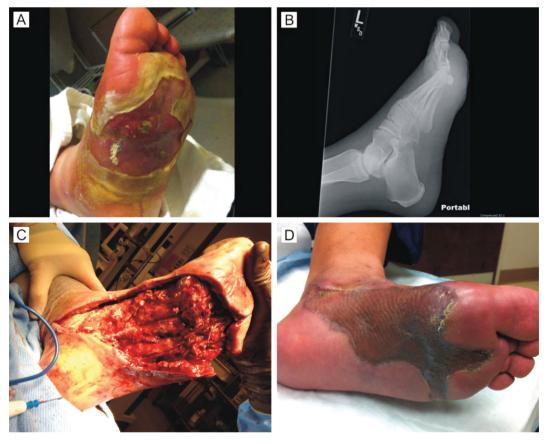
Initial clinical presentation of the left foot with associated erythema, edema, draining deep abscess (A). Radiographic imagining does not show underlying breakdown of bone suggestive of osteomyelitis or Charcot foot (B). Surgical debridement involving entire medial plantar foot as well as sub-metatarsal soft tissue (C). Clinical appearance of healed tissue following negative pressure wound therapy and split thickness skin graft (D).
